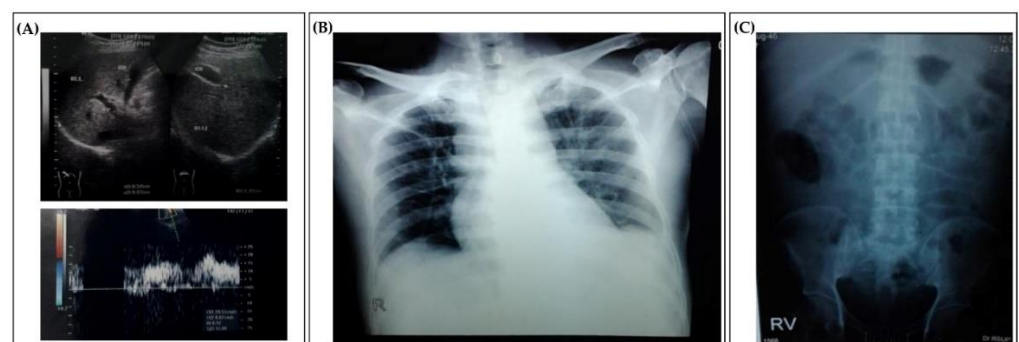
Radiological findings of our patients. (A). The abdominal ultrasound confirmed the presence of cholecystitis and cholelithiasis in the neck of the gallbladder. (B). The chest X-ray
